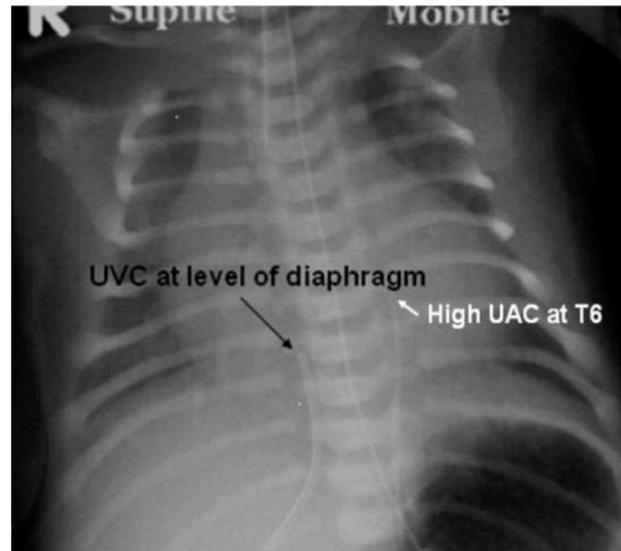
Demonstrating UVC position on x-ray.
